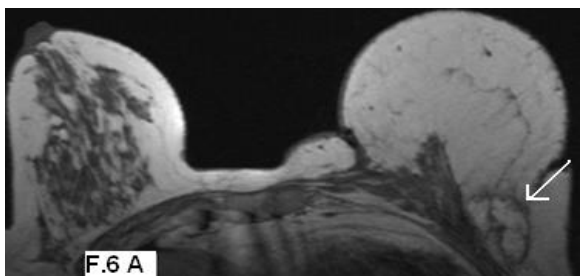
Fat necrosis. 37 year-old female submitted to left lumpectomy 11 months ago for ductal carcinoma. (A) Axial T1WI and (B) T2 FS demonstrate left breast lesion of mixed signal intensities with fat areas (arrow). (C) DWI with b= 800 shows mixed signal lesion(arrow). (D) The ADC map shows a lesion with ADC value of about $1.41 \times 10^{-3} \text{ mm}^2/\text{s}$ (arrow). (E) post-contrast GRE (VIBE) shows heterogeneous enhancement (arrow)
